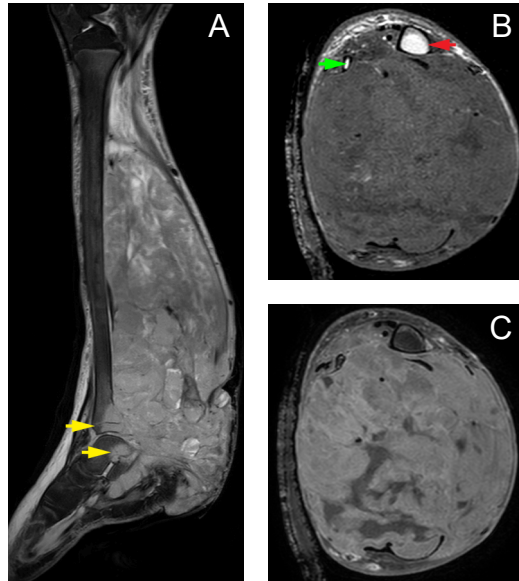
MRI sagittal and axial sections of the right leg. Sagittal STIR image shows a hyperintense signal in the distal metaphysis and growth plate of the right tibia and talus (A: yellow arrows). Axial T1 images with (B) and without contrast (C) show a large heterogeneous mass with muscular extensions/infiltrations and areas of necrosis in the posterior leg. The mass encroaches the interosseous space between the tibia (B: red arrow) and fibula (B: green arrow) and encases the adjacent neurovascular bundles of the right leg exhibiting predominantly isointense signal to muscle.
